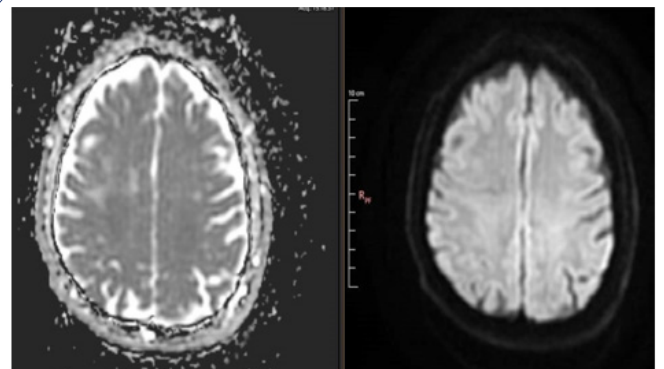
MRI DWI/ADC sequences showing no diffusion restriction.
